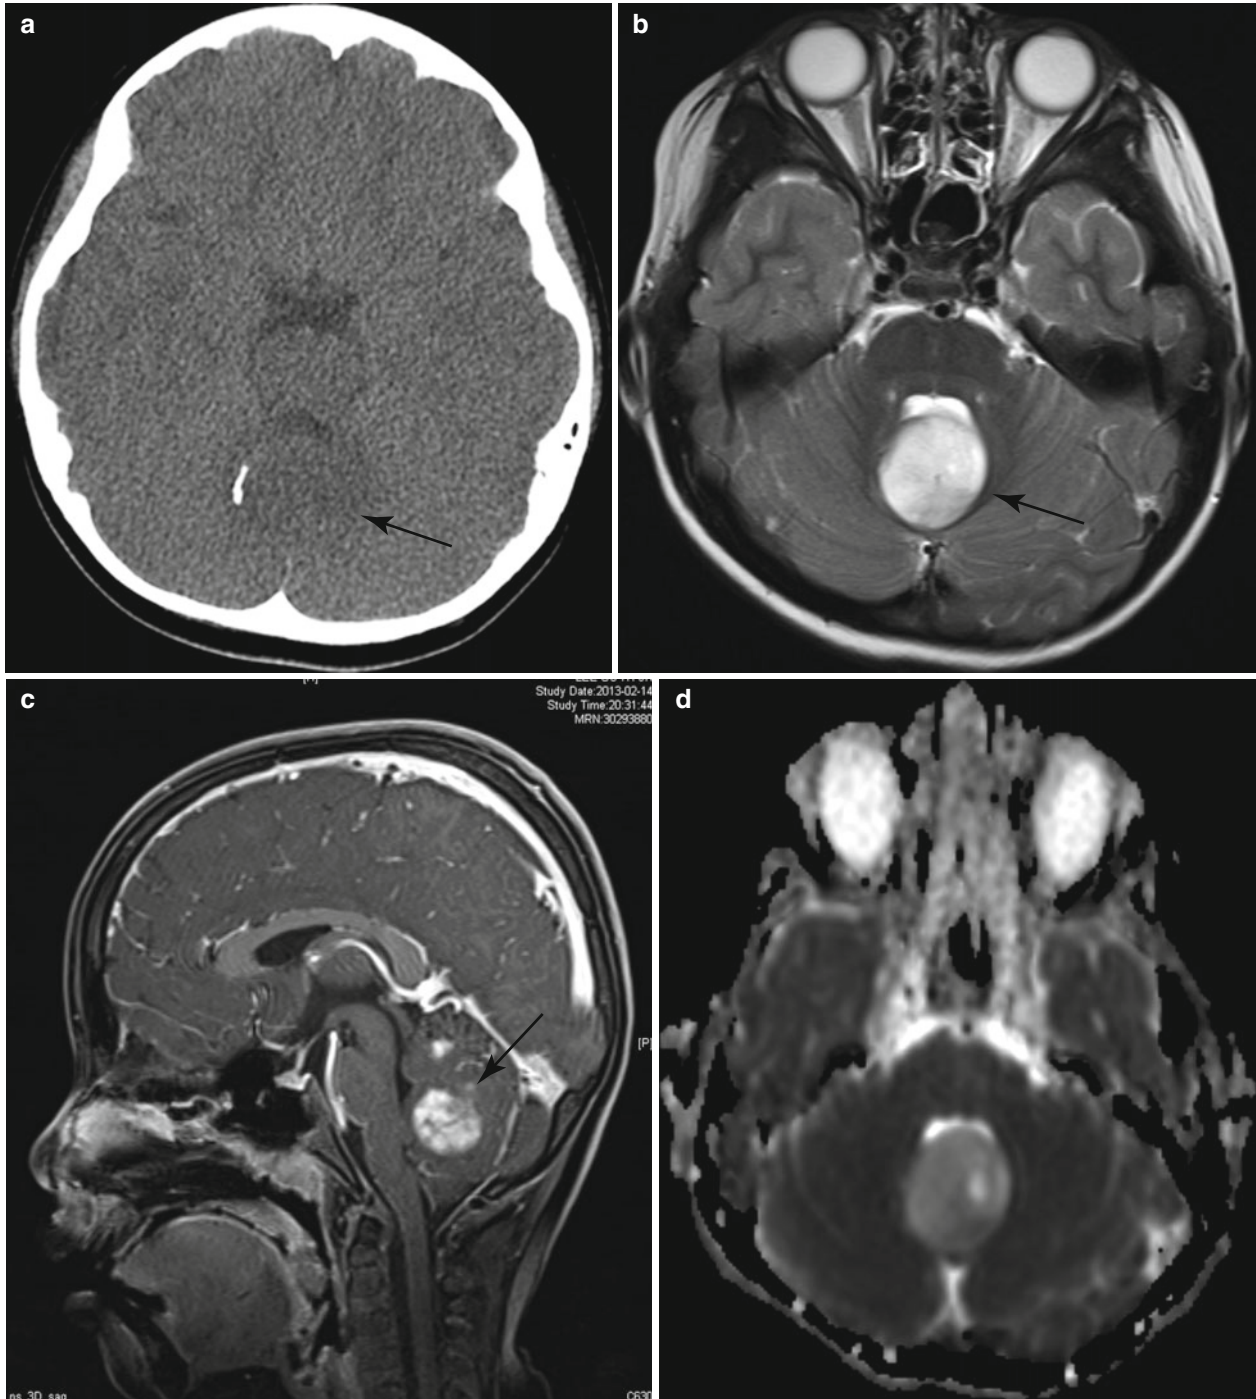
Cerebellar pilocytic astrocytoma in a 7-year-old girl. (a) CT scan shows hypoattenuated mass (*arrow*) with calcification in the midline cerebellum. (b) The mass becomes bright on T2-weighted image, suggesting less compact cellularity. (c) Postcontrast image reveals strong enhancement of the mass. (d) Increased diffusion compared to
